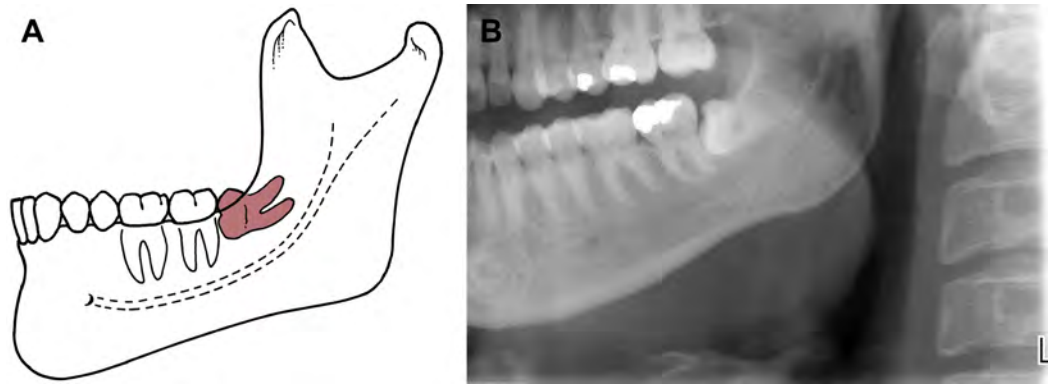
(A) Horizontal mandibular impaction—uncommon and more difficult to remove than a mesioangular impaction. (B) Radiograph of horizontal impacted mandibular third molar. ([A] Adapted from Hupp JR, Ellis E III, Tucker MR, editors. Contemporary oral and maxillofacial surgery. 5th edition. St. Louis: Mosby Elsevier; 2008; with permission. Modified by Ion Syrbu.)
